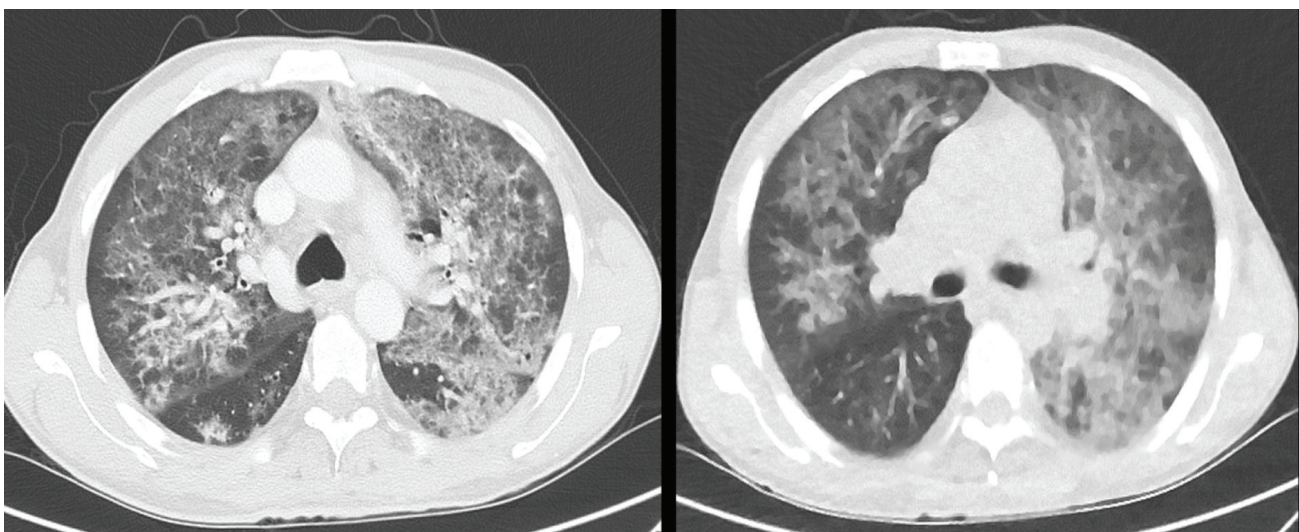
This figure shows the appearance of diffuse ground glass opacity, bronchiectasis, and lung fibrosis in: (a) standard dose and (b) ultra-low dose chest CT image.
